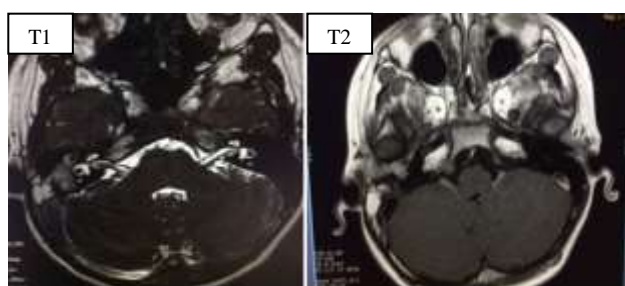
T1 and T2 weighted temporal bone MRI axial views showing a homogenous mass with increased signal intensity relatively to the brain.
